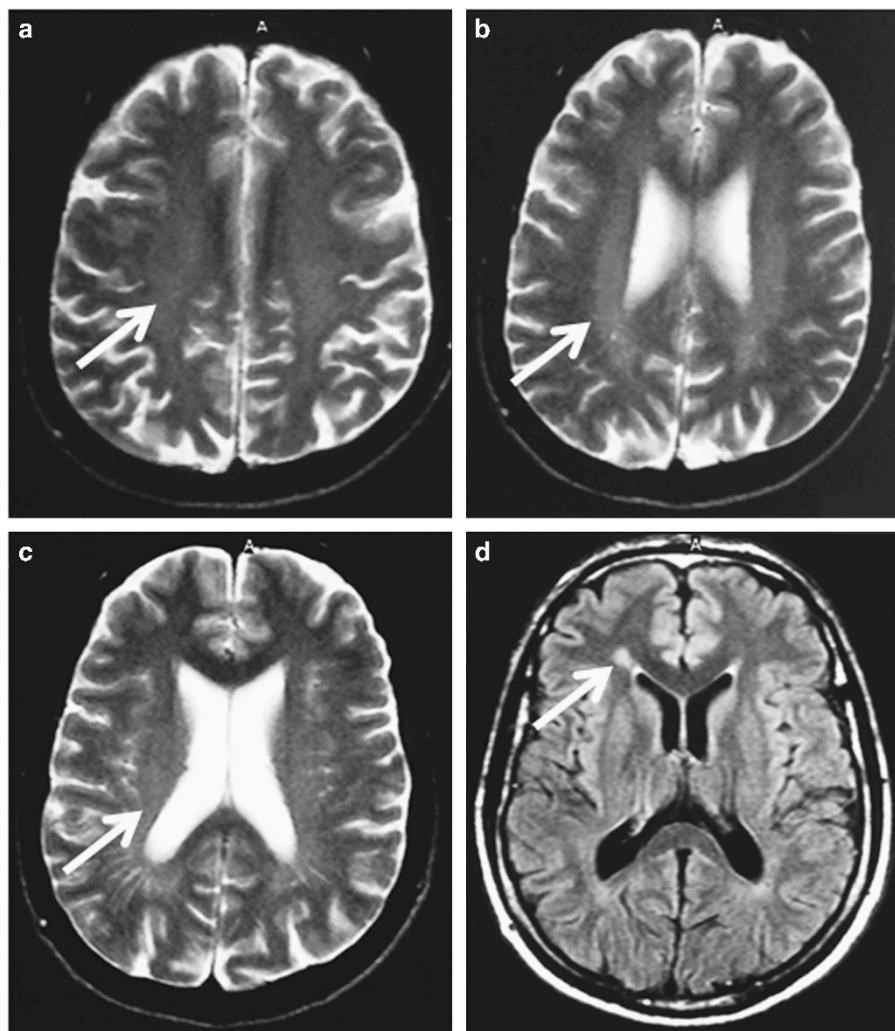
(a–c) axial T2 images showing diffuse periventricular hyperintensity (arrows), along with ventricular and cortical sulci enlargement; (d) axial FLAIR image showing early 'flame-' or 'ears-of-the-lynx-' formation (arrow).
